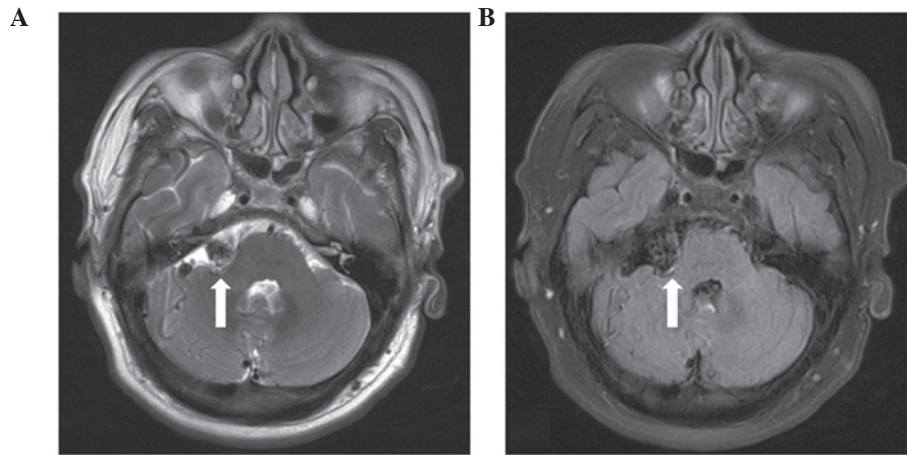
(A) T2-weighted axial MRI and (B) T1-weighted axial MRI showing flow-void signals (arrows) of abnormal vessels in the right cerebellopontine angle prior to the surgical procedure. MRI, magnetic resonance imaging.
